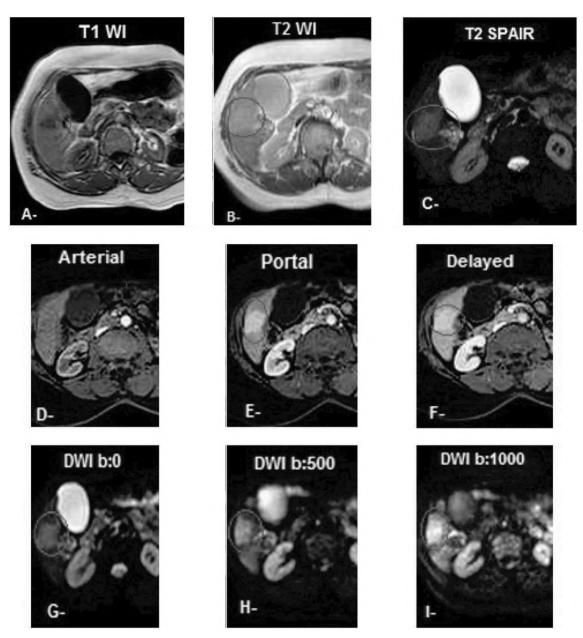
58 year old female patient presented with mild abdominal pain. AFP: 4ng/ml. Dynamic MRI revealed confluent hepatic fibrosis (red circles). Axial unenhanceded T1WI (A), T2WI (B) and T2SPAIR (C), shows patchy wedge-shaped area of low signal intensity at right lobe of the liver, (segment V) having hypointense T1WI, bright T2WI and T2 SPAIR images Axial T1-weighted spoiled gradient-echo MR im-age obtained in the arterial phase, (D), portal phase (E) and delayed venous phase (F) showed no significant enhancement of the lesion in the arterial phase, with delayed enhancement in the portal and delayed phases, a characteristic finding of fibrosis. Capsular retraction secondary to subtle volume loss is also seen. (best seen in the dynamic phases). The ADC value (not shown) was 1.32X10⁻³.
